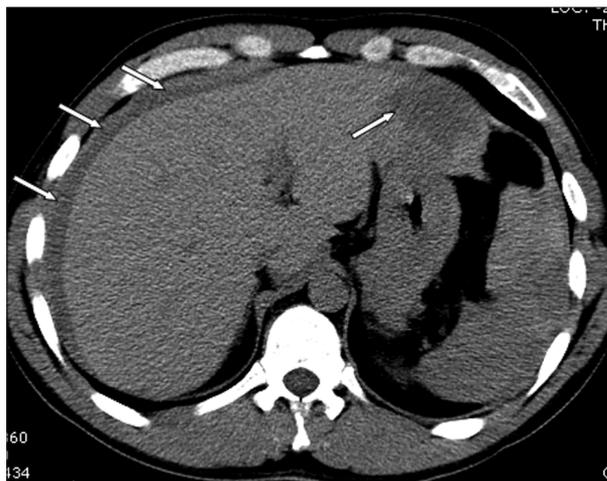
CT of abdomen showing blood in the abdominal cavity, and surrounding the liver.
